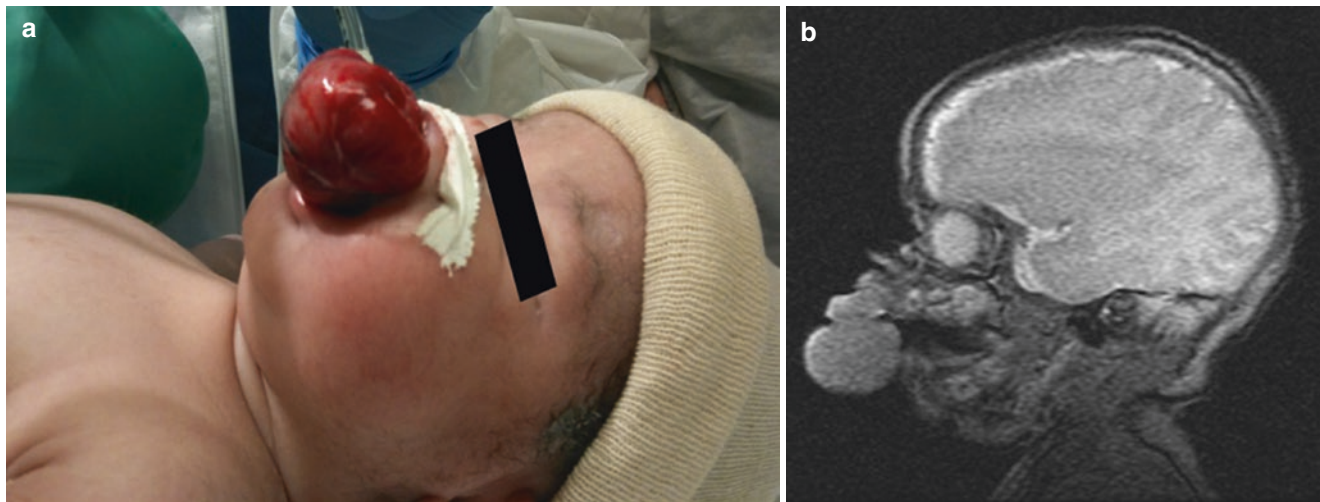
(a) Neonate with a hamartoma of the hard palate. (b) CT scan of the neonate demonstrating a clear and patent nasopharyngeal airway
